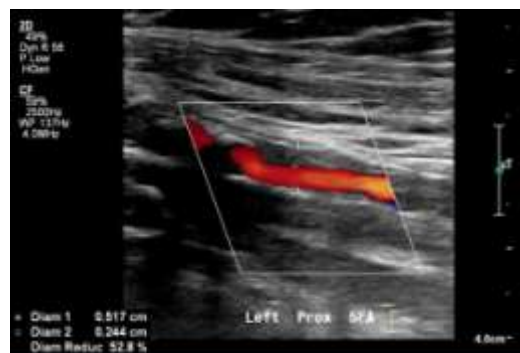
Doppler USG show around 52% narrowing in proximal SFA by plaque.
